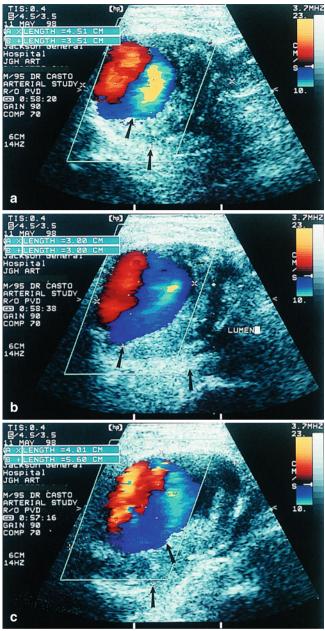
(a) A color duplex ultrasound image showing a right common femoral artery aneurysm in transverse view that measures around 4.51 cm in transverse diameter, and 3.51 cm in AP diameter. Please notice the presence of thrombus between the outside wall as indicated by the outside *arrow*, and the inside lumen as indicated by the inside *arrow*. (b) A color duplex ultrasound image showing the same patient as in (a) with measurement of the inside lumen (3 cm in transverse diameter and 3 cm in AP diameter). Notice the thrombus between the inside lumen and the outside wall (*arrows*). (c) A color duplex ultrasound image showing the same patient as in (a) with an aneurysm measuring 5.6 cm in length and 4.01 cm in AP diameter (*longitudinal view*)
